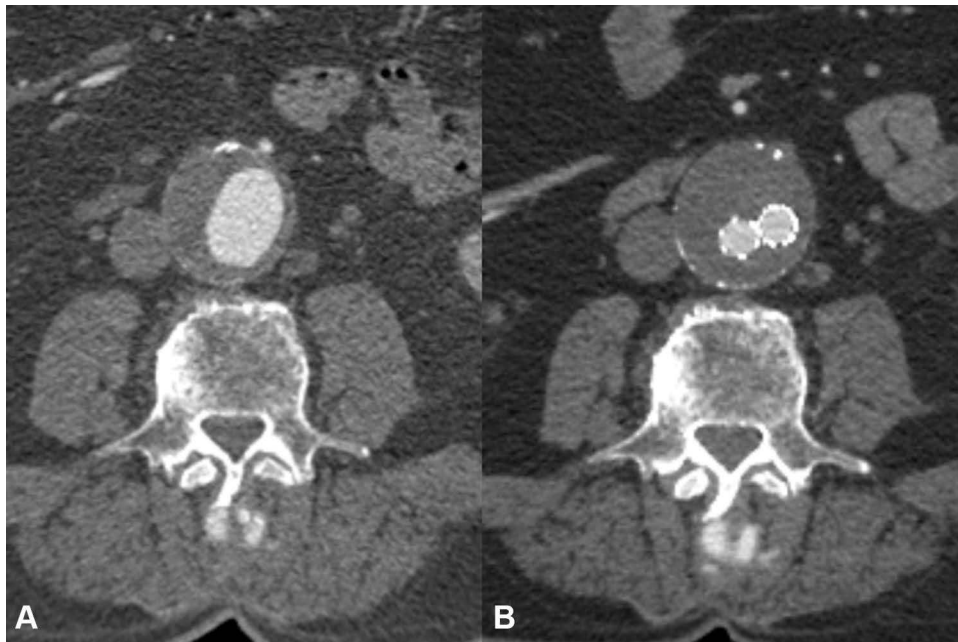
CTA scans showing abdominal aortic aneurysm before treatment (A) and after three months (B). An aneurysm sac enlargement is visible despite there was no EL.
